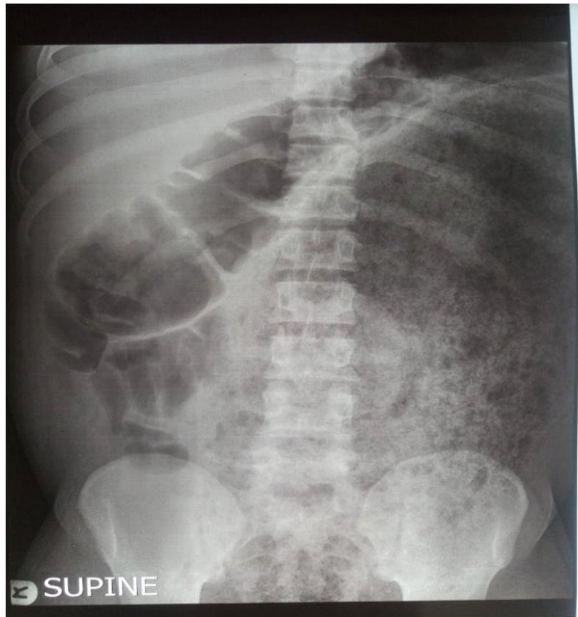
Abdominal plain radiograph (supine view)
